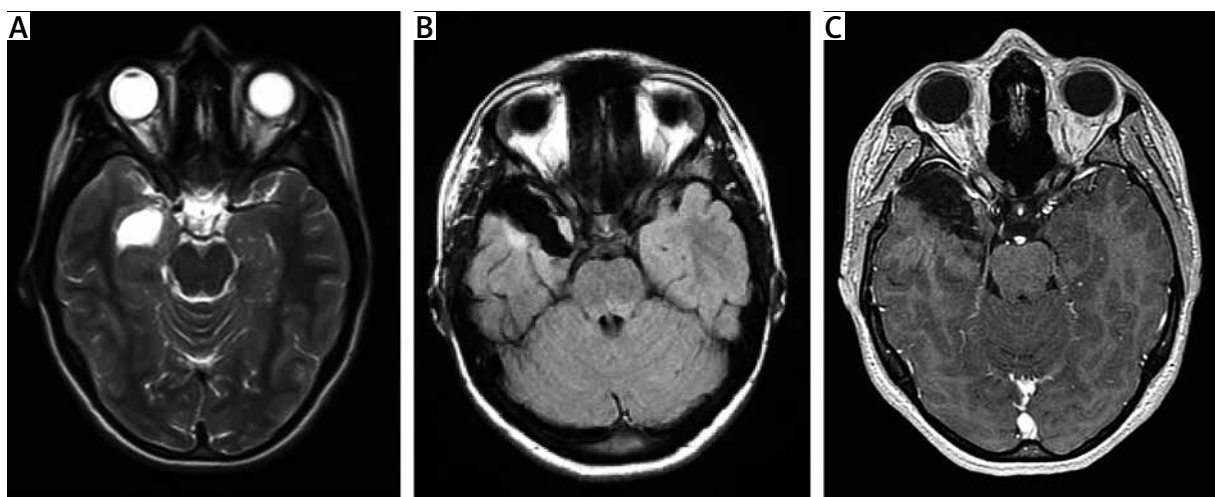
MRI feature. Case 1. A) Preoperative MR brain examination. Axial T2-weighted image showing a well-delineated hyperintense lesion located in the right temporal lobe. B, C) Post-operative MR images. Axial FLAIR (B) and postcontrast T1-weighted (C) images showing a resection cavity with the small hyperintense area – gliosis. No contrast enhancement.
